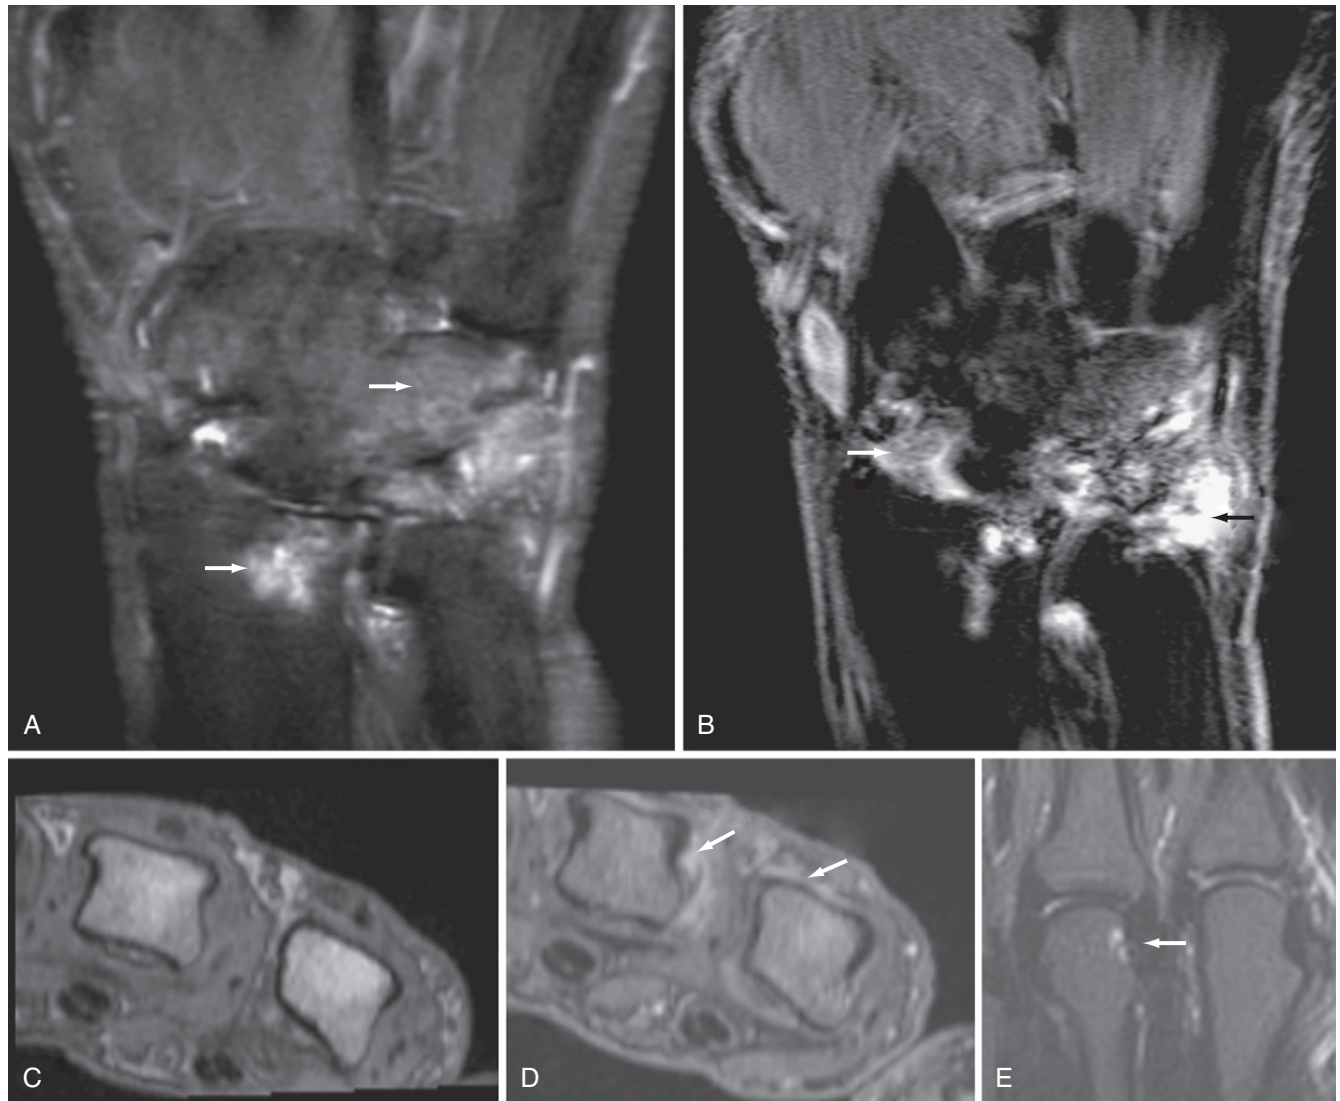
Rheumatoid arthritis (RA) in clinical remission (magnetic resonance imaging [MRI]) and undifferentiated arthritis (MRI). A and B, RA patient in clinical remission. Despite clinical remission, coronal short tau inversion recovery (STIR) (A) and postcontrast T1-weighted fat-suppressed (B) MRI show marked bone marrow edema (osteitis, arrows in A) and synovitis (arrows in B). C through E, Patient with undifferentiated arthritis. Axial T1-weighted precontrast (C) and postcontrast (D) T1-weighted MRI views show synovitis in second and third metacarpophalangeal joints (arrows), whereas the STIR sequence (E) shows bone edema (arrow). X-ray was normal. One year later the patient had developed RA, according to the American College of Rheumatology 1987 criteria. (Courtesy Dr. Anne Duer-Jensen, Glostrup, Denmark.)
